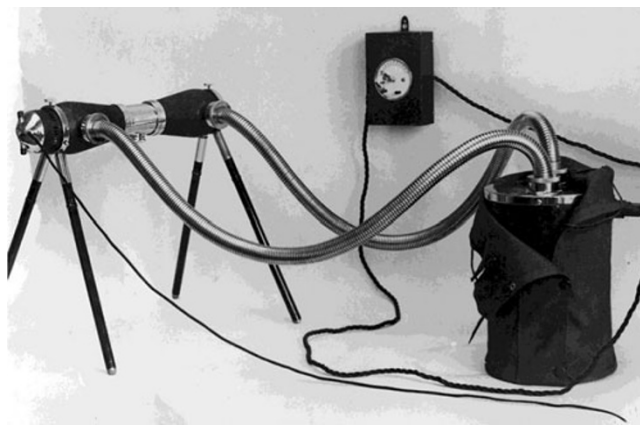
Early electrically shockproof X-ray unit, the portable Philips Metalix Junior (1928) [48]
